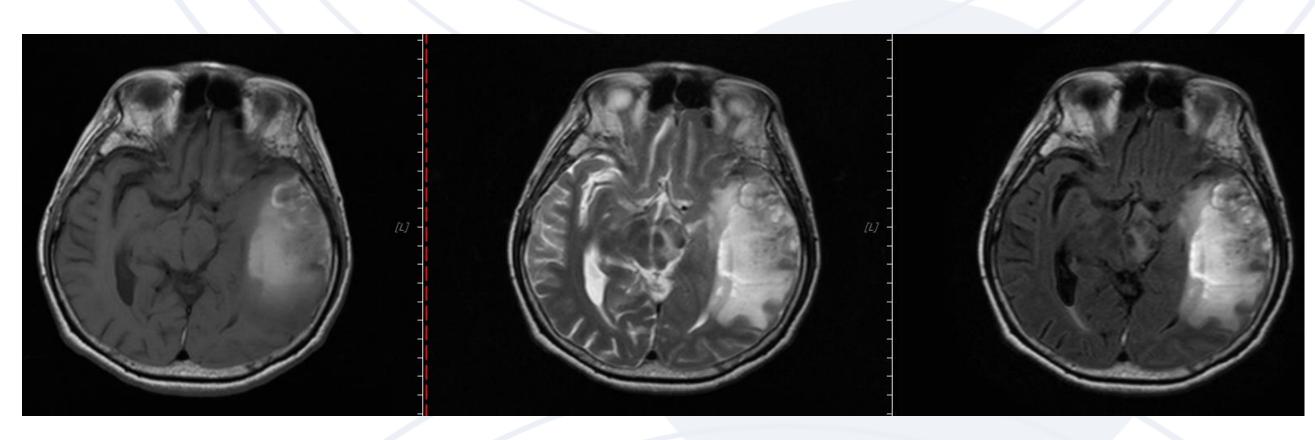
Magnetic resonance imaging of the brain confirmed blood products of varying ages and oedema.
